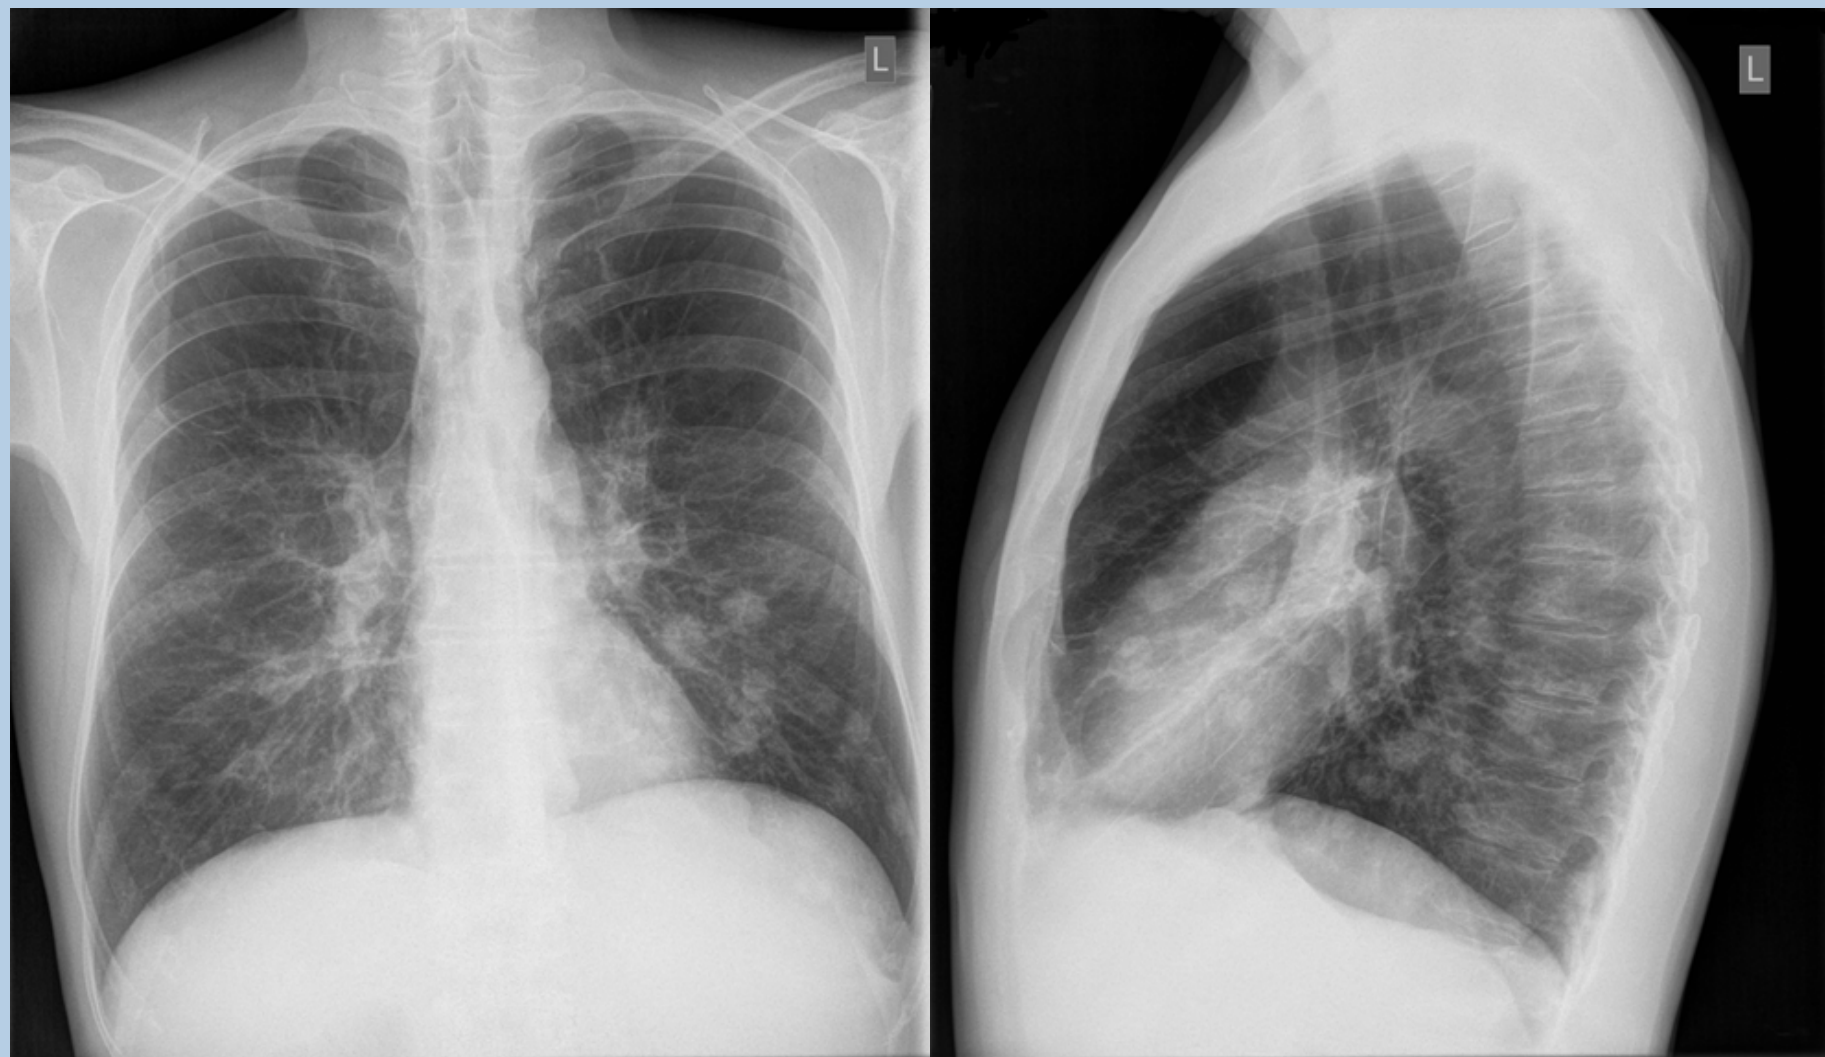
Chest radiograph May 2011
